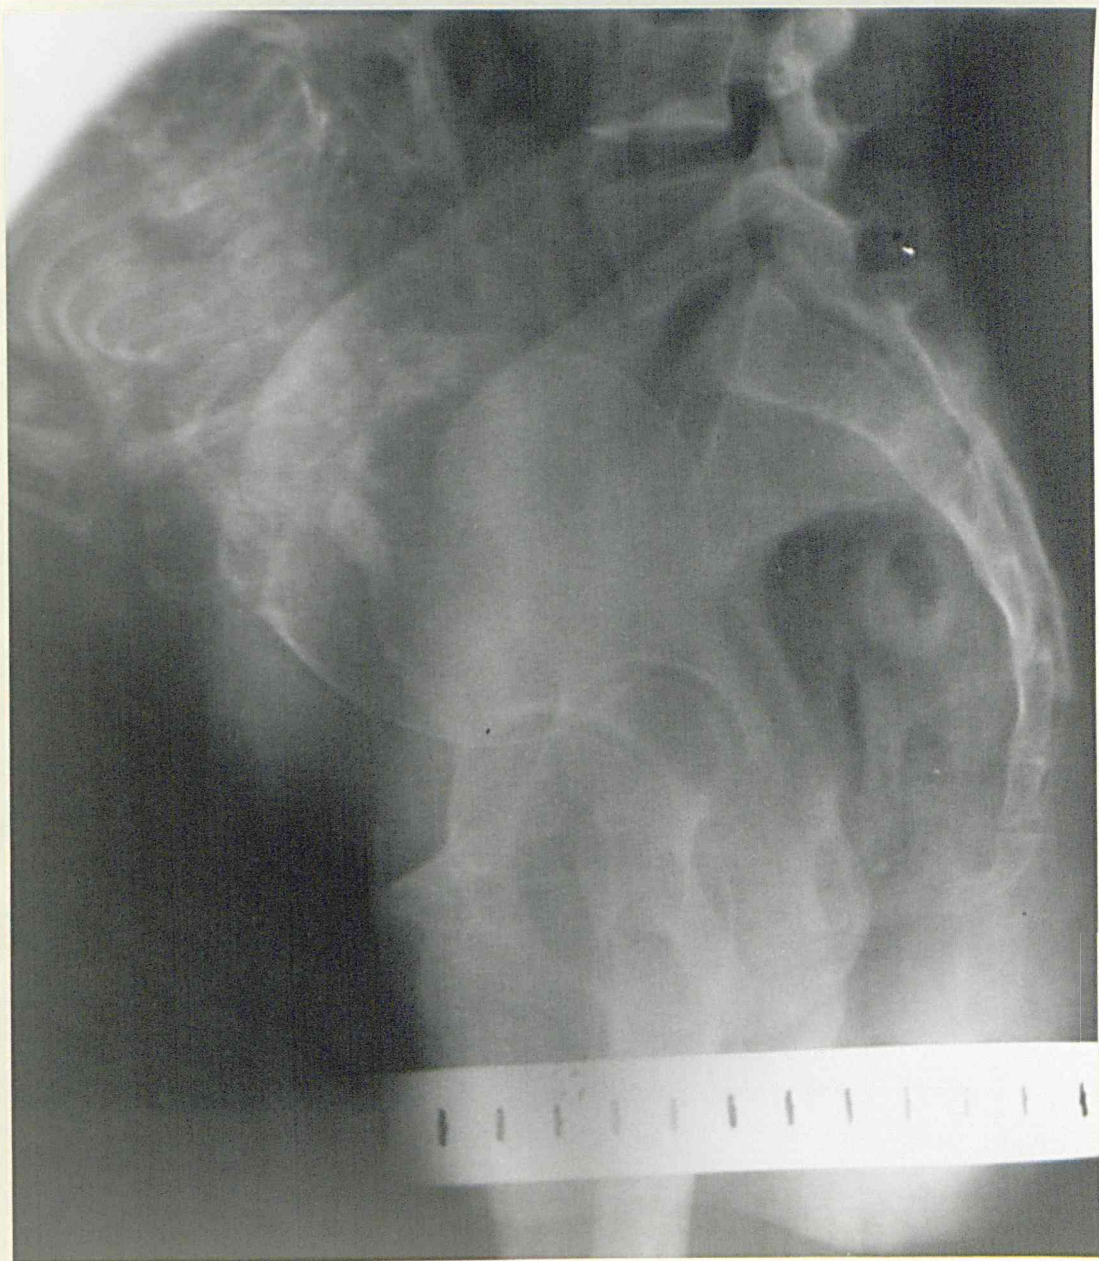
Erect lateral radiograph in a case of anterior placenta praevia. The head is displaced backwards from the symphysis and there is a marked thickening of the anterior "band-like" shadow. (Recent case. Delivered by Caesarean section. Anterior placenta praevia type I).
